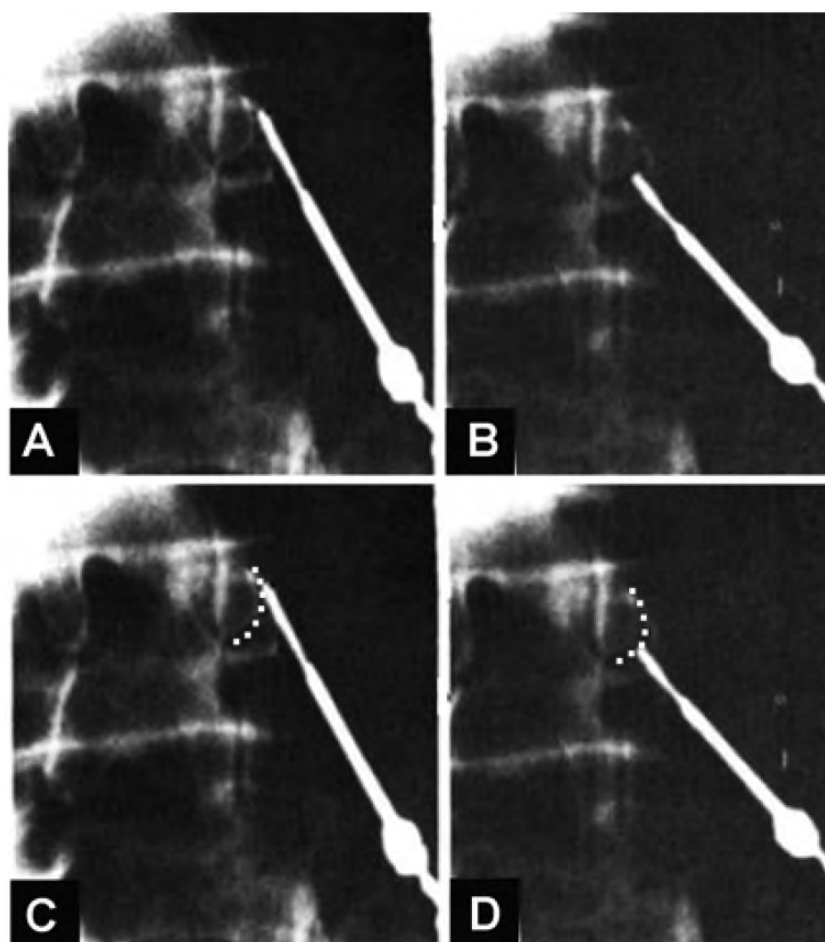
Radiographs of electrodes placed for lumbar radiofrequency neurotomy, published in 1979 [60]. A and B) Copies of the original radiographs. The technique recommends placing a lesion proximally and distally along the course of the nerve. In (C and D), the course of the medial branch has been depicted as a dotted line. It is evident that the tip of the electrode lies on the target nerve in each position.
